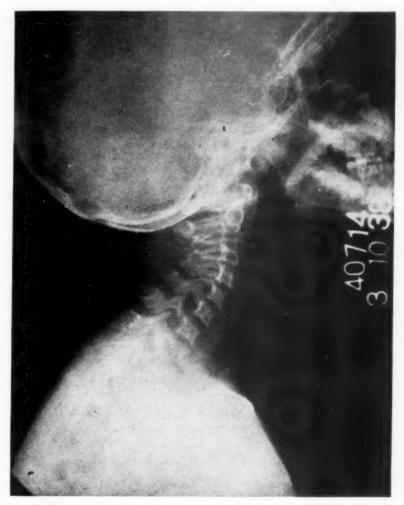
Lateral roentgenogram of cervical spine showing decalcification, distortion and atrophy of cervical vertebral bodies adjoining a large cervical neurofibroma.
